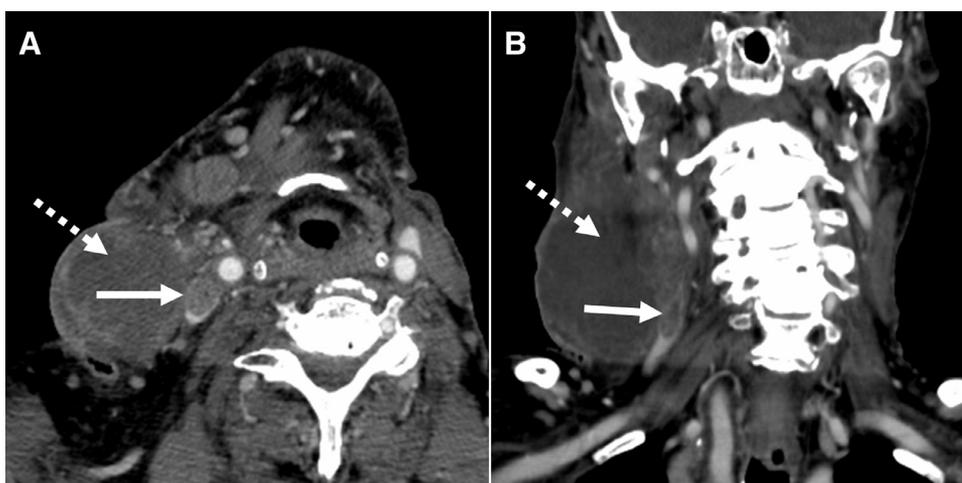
A 94-year-old male with known soft tissue sarcoma presents with neck swelling and fever. A contrast-enhanced CT examination in the axial (A) and coronal planes (B) demonstrates a large soft tissue mass that is inseparable from the right sternocleidomastoid muscle (A-B, dashed arrows). There is directed extension of tumor from the neck into the adjacent right internal jugular vein (A-B, solid arrows) consistent with tumor thrombus.
